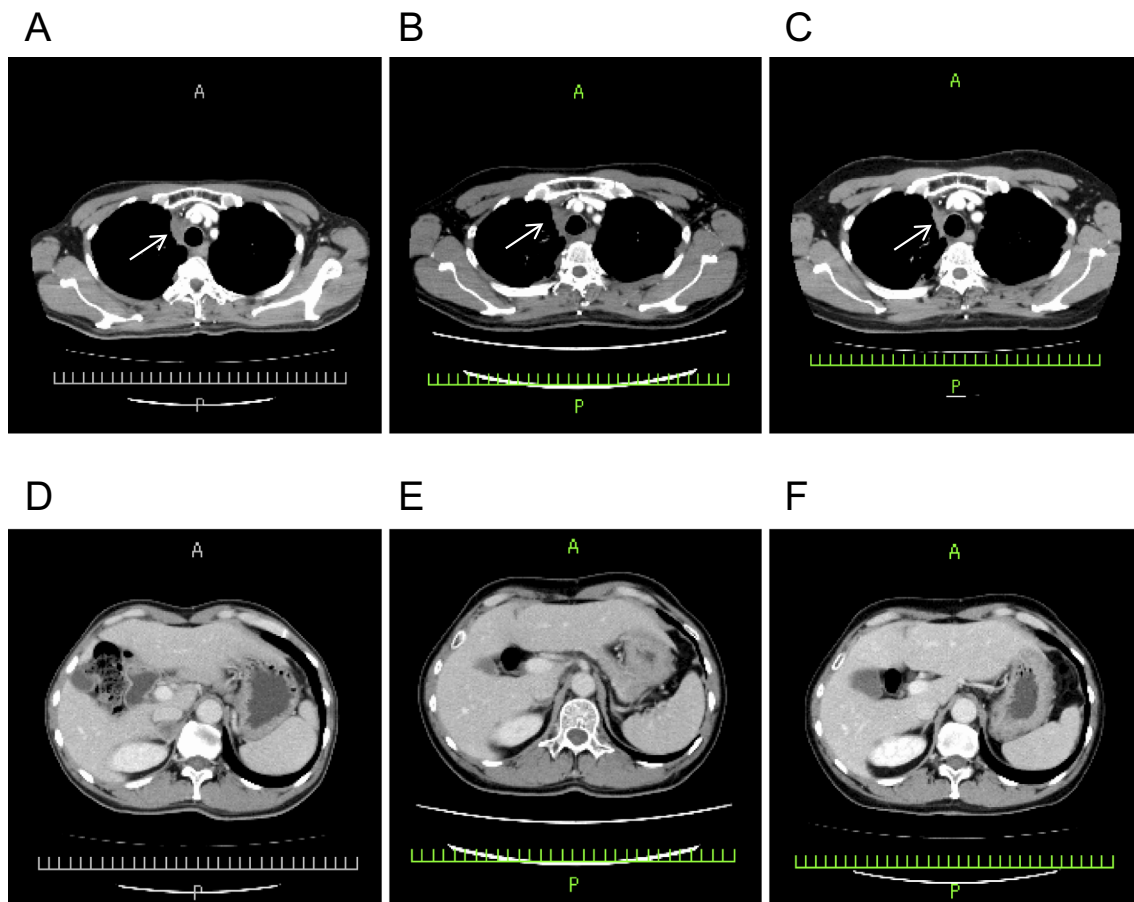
Computed tomography (CT) revealed the shrinkage of the primary lesion (arrow) and the right adrenal gland metastasis before pembrolizumab (A and D), after four cycles of pembrolizumab (B and E), and after eight cycles of pembrolizumab (C and F).
